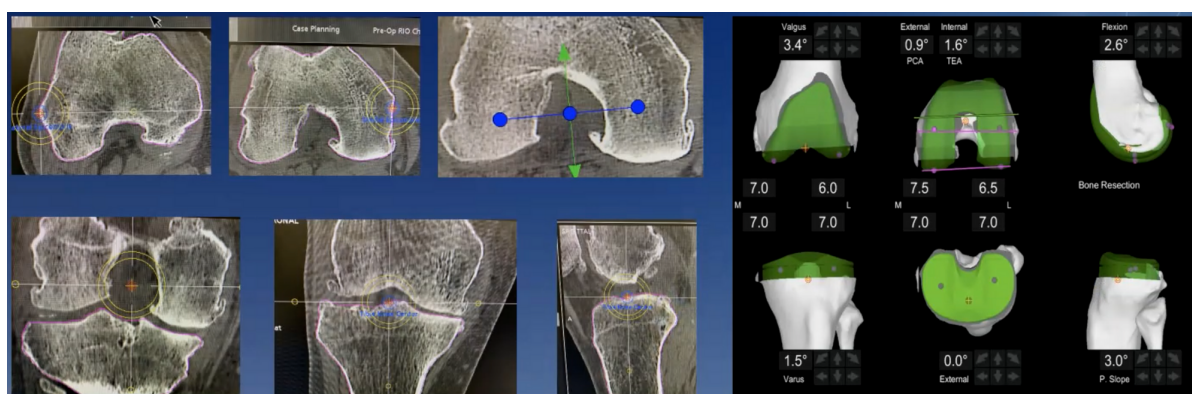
The CT-based systems provide a 3D reconstruction of the patient knee and global anatomy of the lower limb. The precise anatomical landmarking and alignment allow 3D pre-operative planning of TKA.
